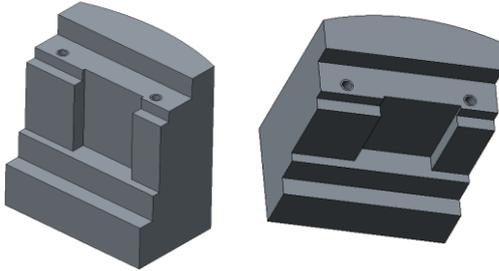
Counterweights used with fluoroscopy C-arm X-ray. Simple to make from lead, but much more difficult with tungsten.
